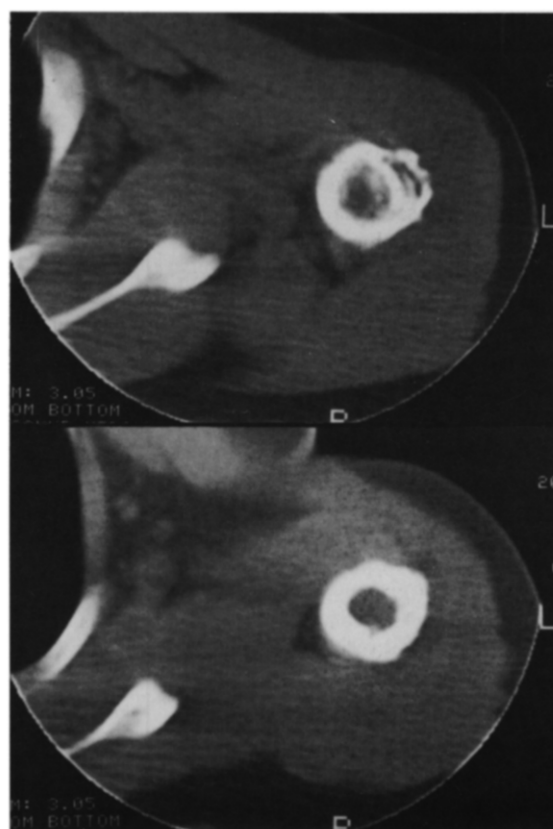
CT through the tumour at two levels showing penetration of the cortex with lateral spread into the soft tissues.
